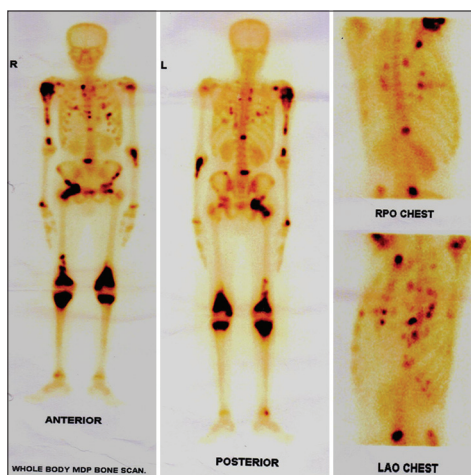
A 15-year-old child with synchronous MOGS-whole body bone 99m technetium-MDP scintigraphy revealed intense tracer uptake involving multiple skeletal sites. Few sites of uptake were also noted in ribs, which mimic pulmonary metastasis, however, the same was ruled out on oblique views. MOGS = Multifocal osteogenic sarcoma, MDP = Methylene diphosphonate
